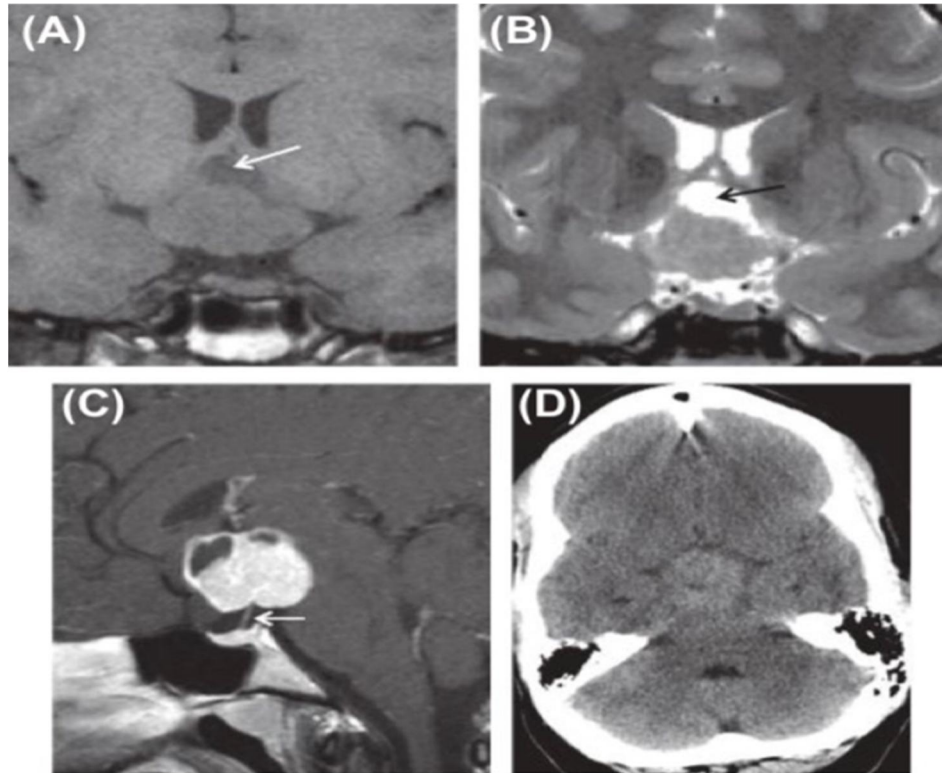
A, Coronal, T1-weighted MR image shows a lobulated, suprasellar mass that is isointense relative to parenchyma; a cystic-appearing portion (arrow) that is only mildly hyper intense relative to CSF is seen superiorly. B, Coronal, T2-weighted MR image also shows a lobulated, suprasellar mass that is isointense to the parenchyma; the cystic-appearing portion (arrow) is hyper intense. C, Sagittal, T1-weighted enhanced MR image shows mostly solid enhancement of the mass. The infundibulum (arrow) is not displaced posteriorly (compare to chordoid glioma, Figure 3.16). D, Axial, non-contrast CT image shows a mass that is isodense to parenchyma; no calcification is seen.
